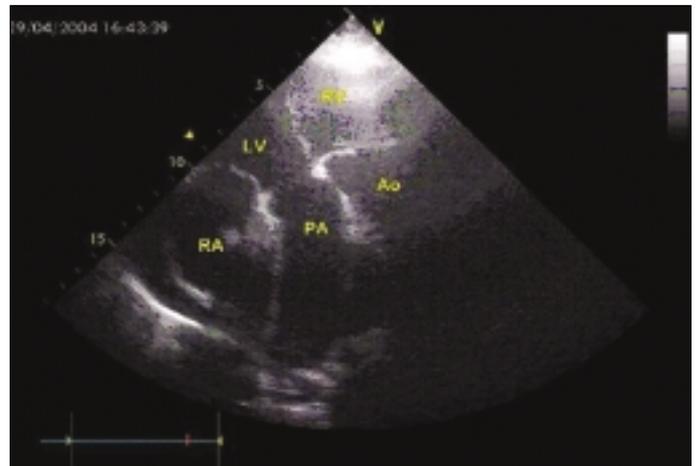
Transthoracic echocardiography showed transposition of great arteries
